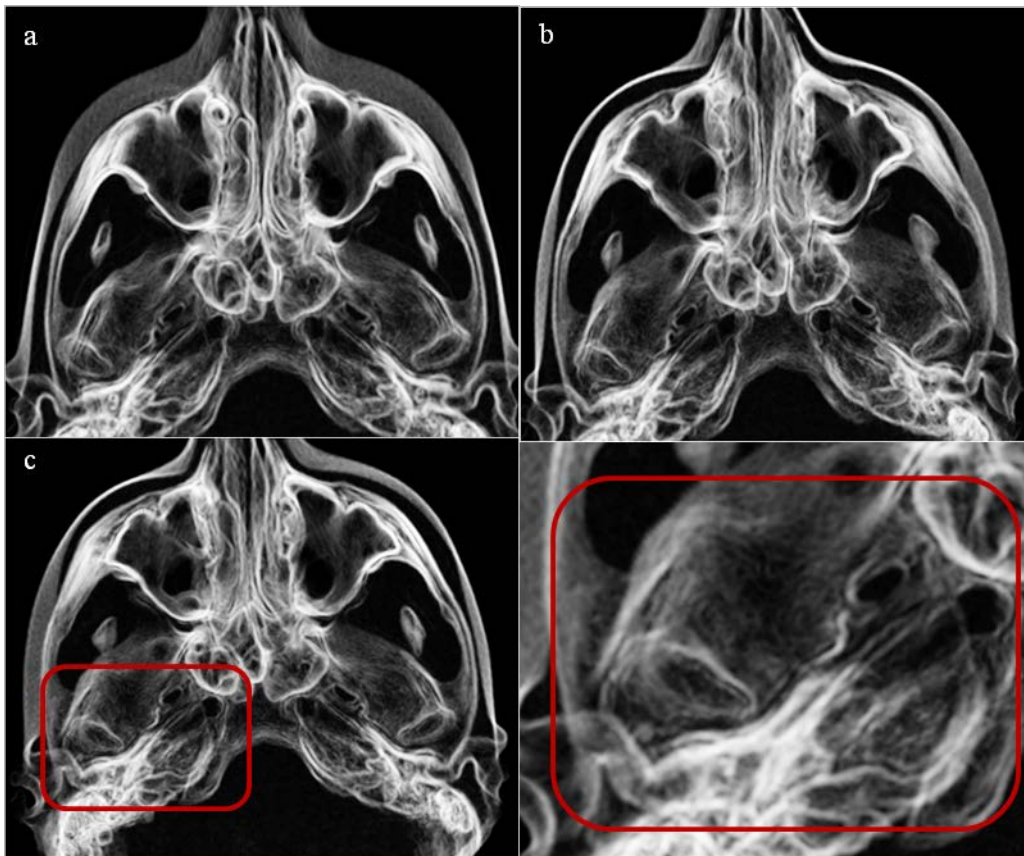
Analysis of the CBCT data after applying our EPF, in the same patient of figure 6. As it is a 3D object, we are able to rotate the figure to observe, from different planes, the anatomic parts of the TMJ. Therefore it is also possible to observe the articular disk (arrowhead) and its differences in a, b and c. Once we are satisfied with the result of the image, we select that area and we zoom on it to obtain an intensified view, as in panel (c).
